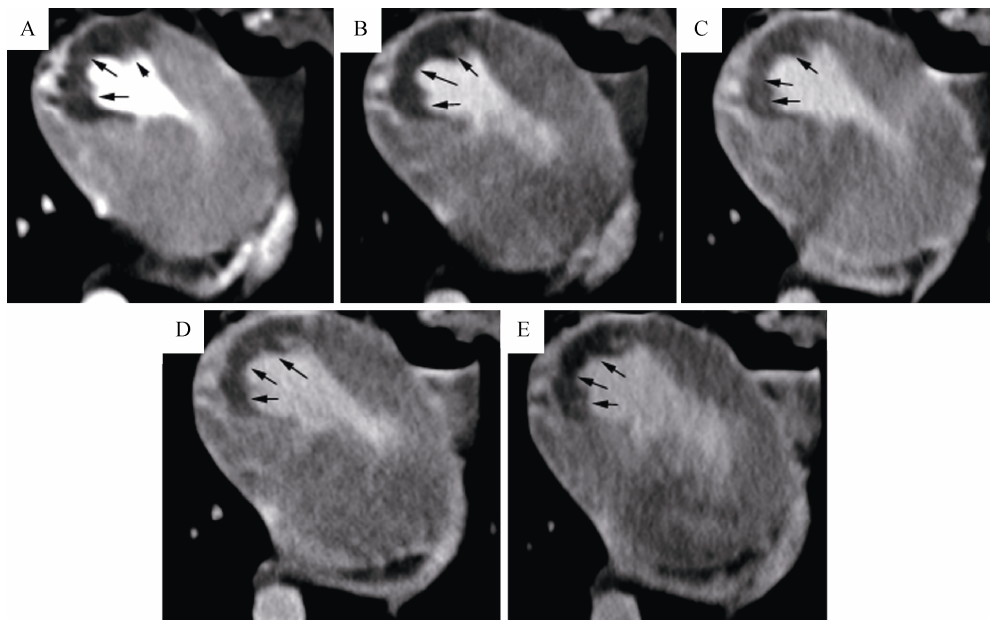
Multi-slice computed tomography (MSCT) myocardial image at various time-points. Images at 1 min (A), 5 min (B), 10 min (C), 15 min (D), and 20 min (E) after contrast injection. Dark zone (black arrows) indicates perfusion defects in the infarcted region.
